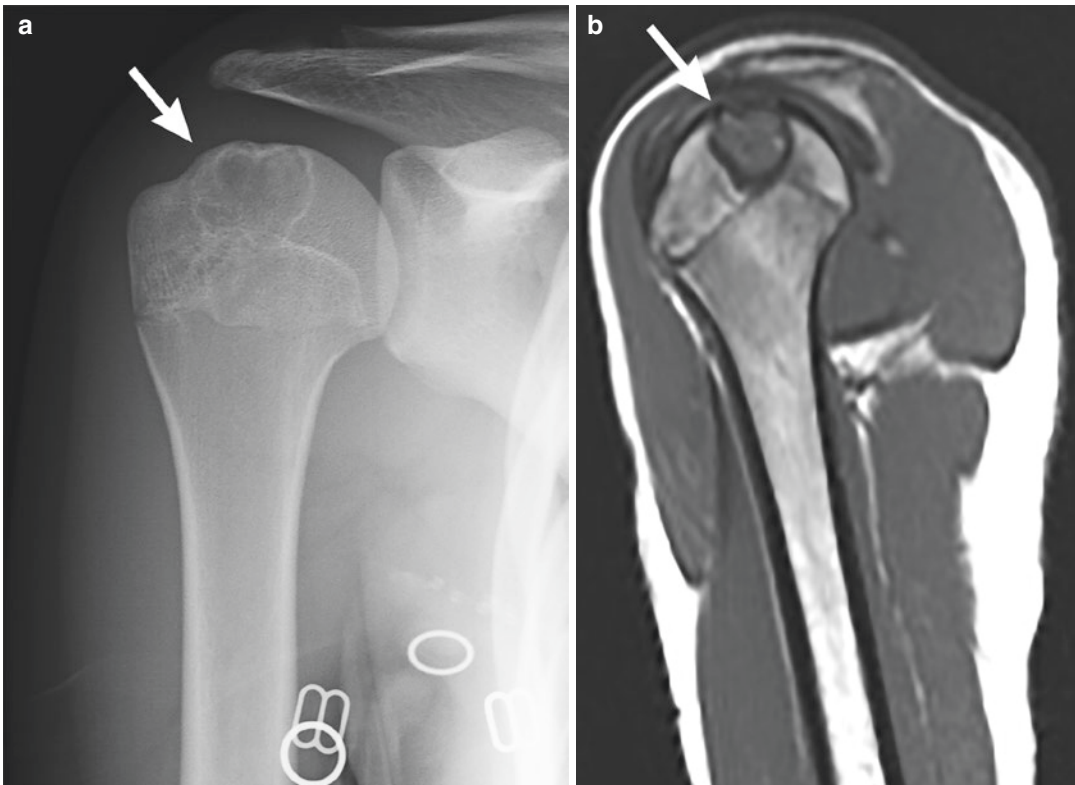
Chondroblastoma in a 15-year-old girl with a history of crepitus and pain in the right shoulder. (a) AP radiographs show a well-demarcated lytic lesion with sclerotic borders in the proximal humeral metaphysis (arrow). No periosteal reaction is seen. (b) Sagittal T1-WI
